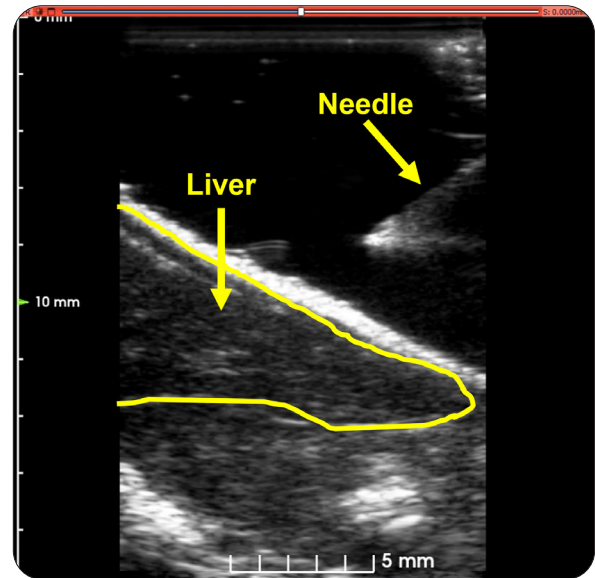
Example ultrasound image of the liver.
